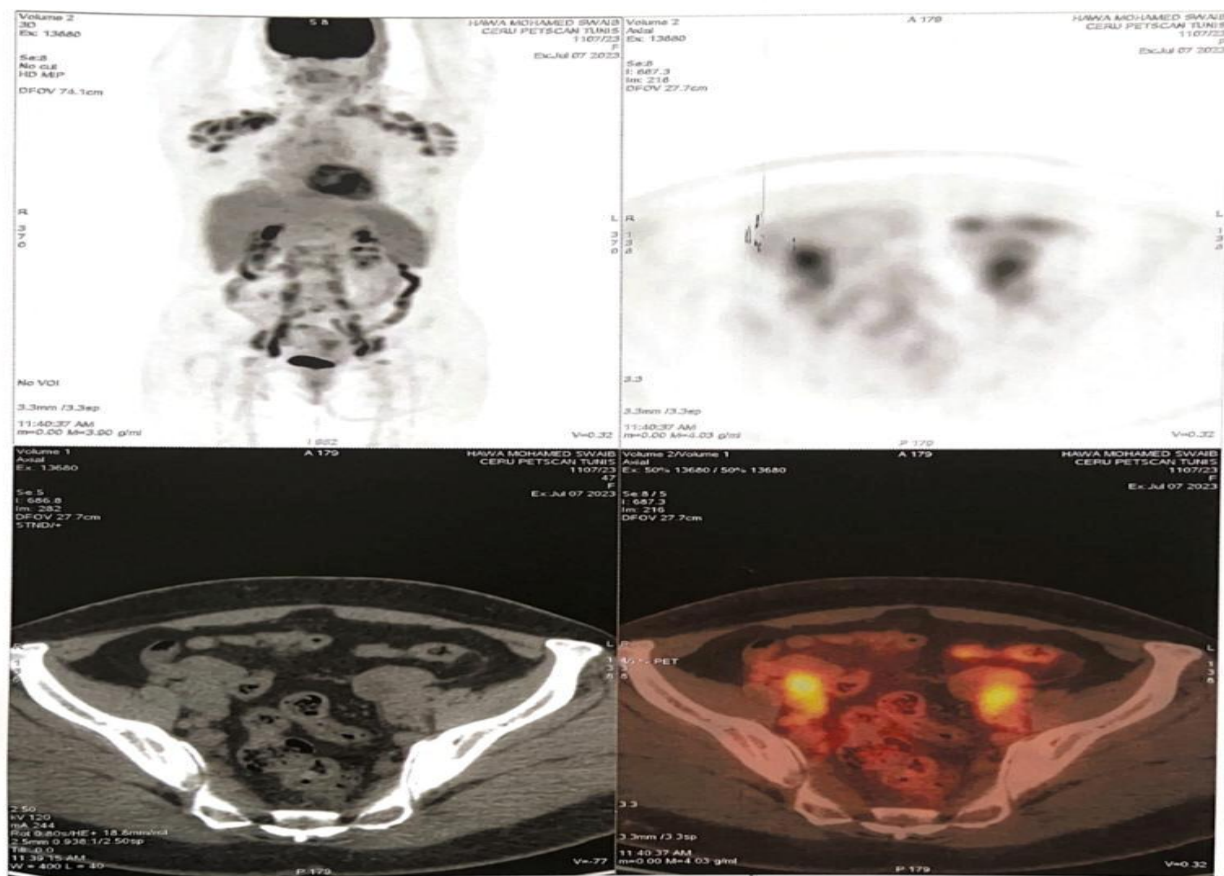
PET-CT imaging highlighting significant FDG-avid nodes in the iliac and inguinal stations.
